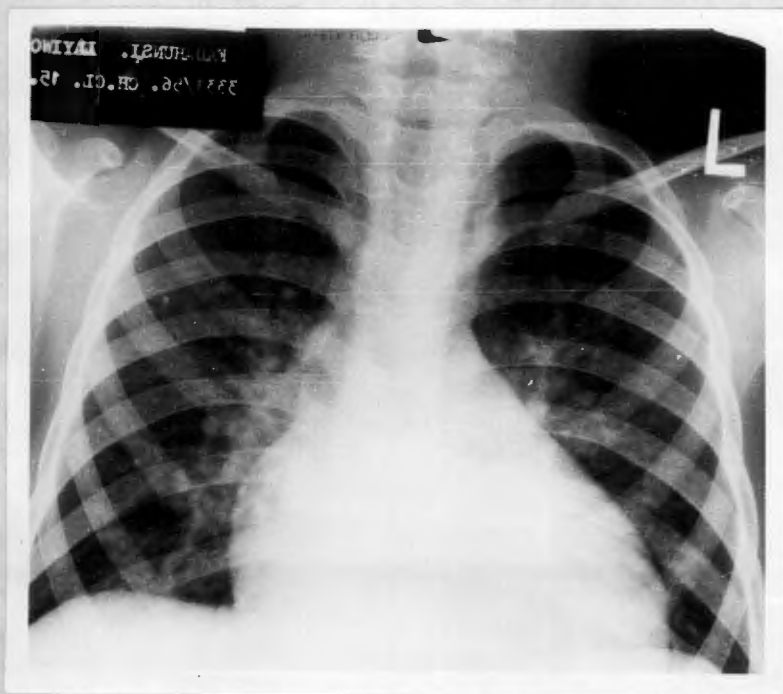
to 28 show chest X-rays in 4 of our cases and demonstrate the variability of the cardiac size and shape.
